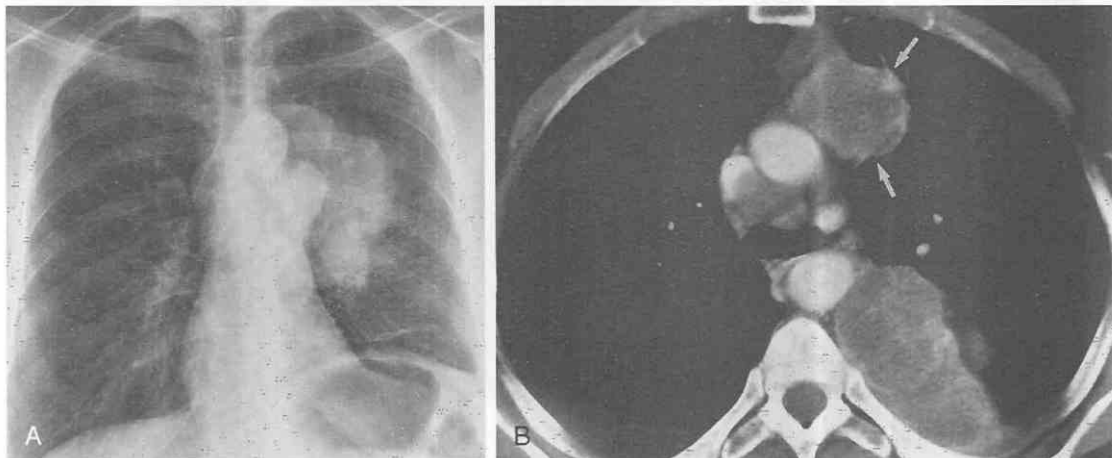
Small-cell lung cancer in a 50-year-old woman with diaphragmatic paralysis resulting from phrenic nerve involvement. *A*, Posteroanterior chest radiograph shows a large lobular mass in the left lower lobe and elevation of the left hemidiaphragm. *B*, CT reveals a necrotic mass in the left lower lobe and mediastinum (arrows) in the anatomic location of the phrenic nerve.
